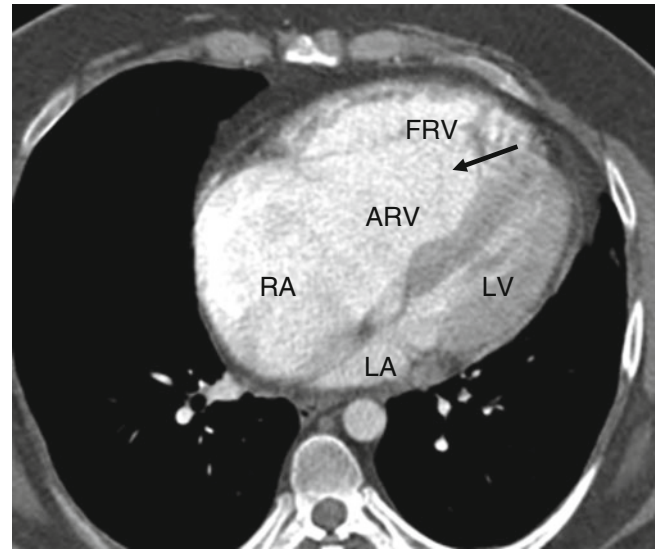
Ebstein anomaly. An axial computed tomographic scan showing a dilated right atrium (RA), atrialized right ventricle (ARV), and a small functional right ventricle (FRV). Note the apical displacement of the septal tricuspid leaflet (black arrow). LA left atrium, LV left ventricle
